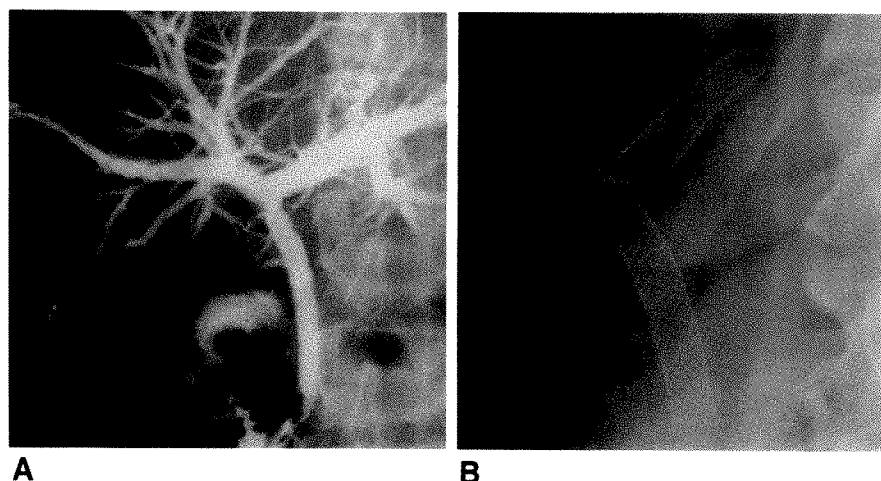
Radiographs of 76-year-old man with cholangiocarcinoma.
